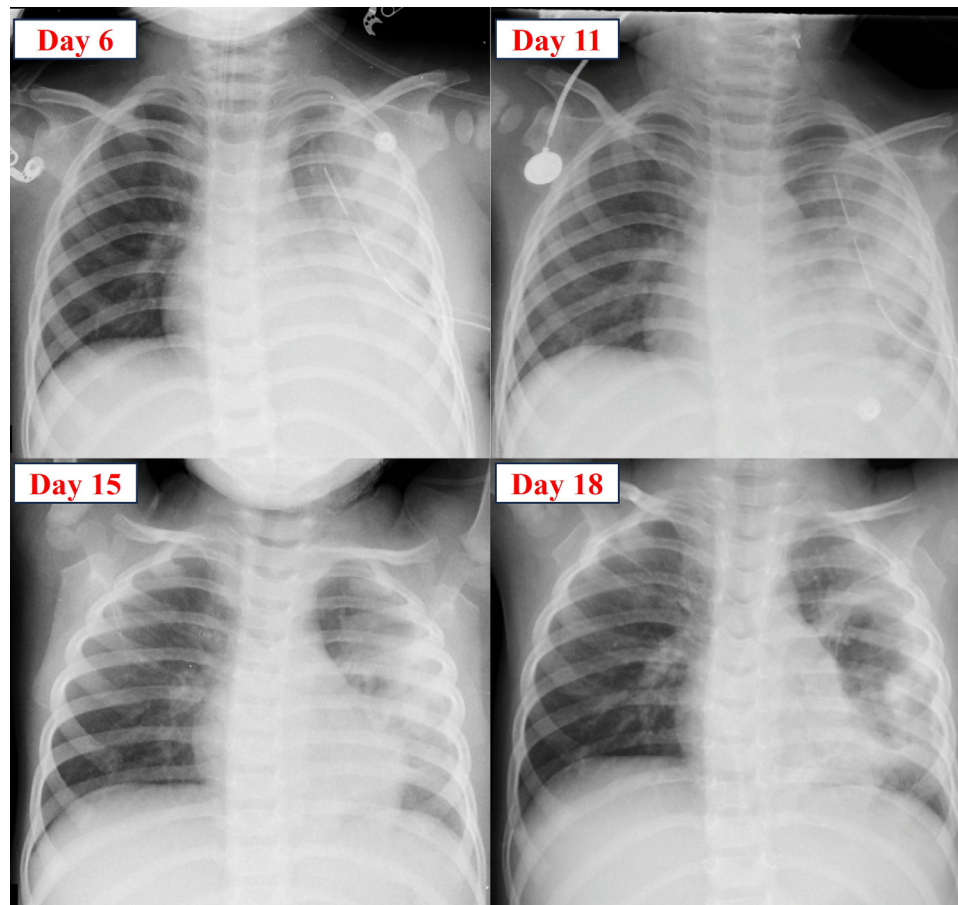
Progression of the patient's chest X-ray from the sixth day to the 18th day of treatment.
